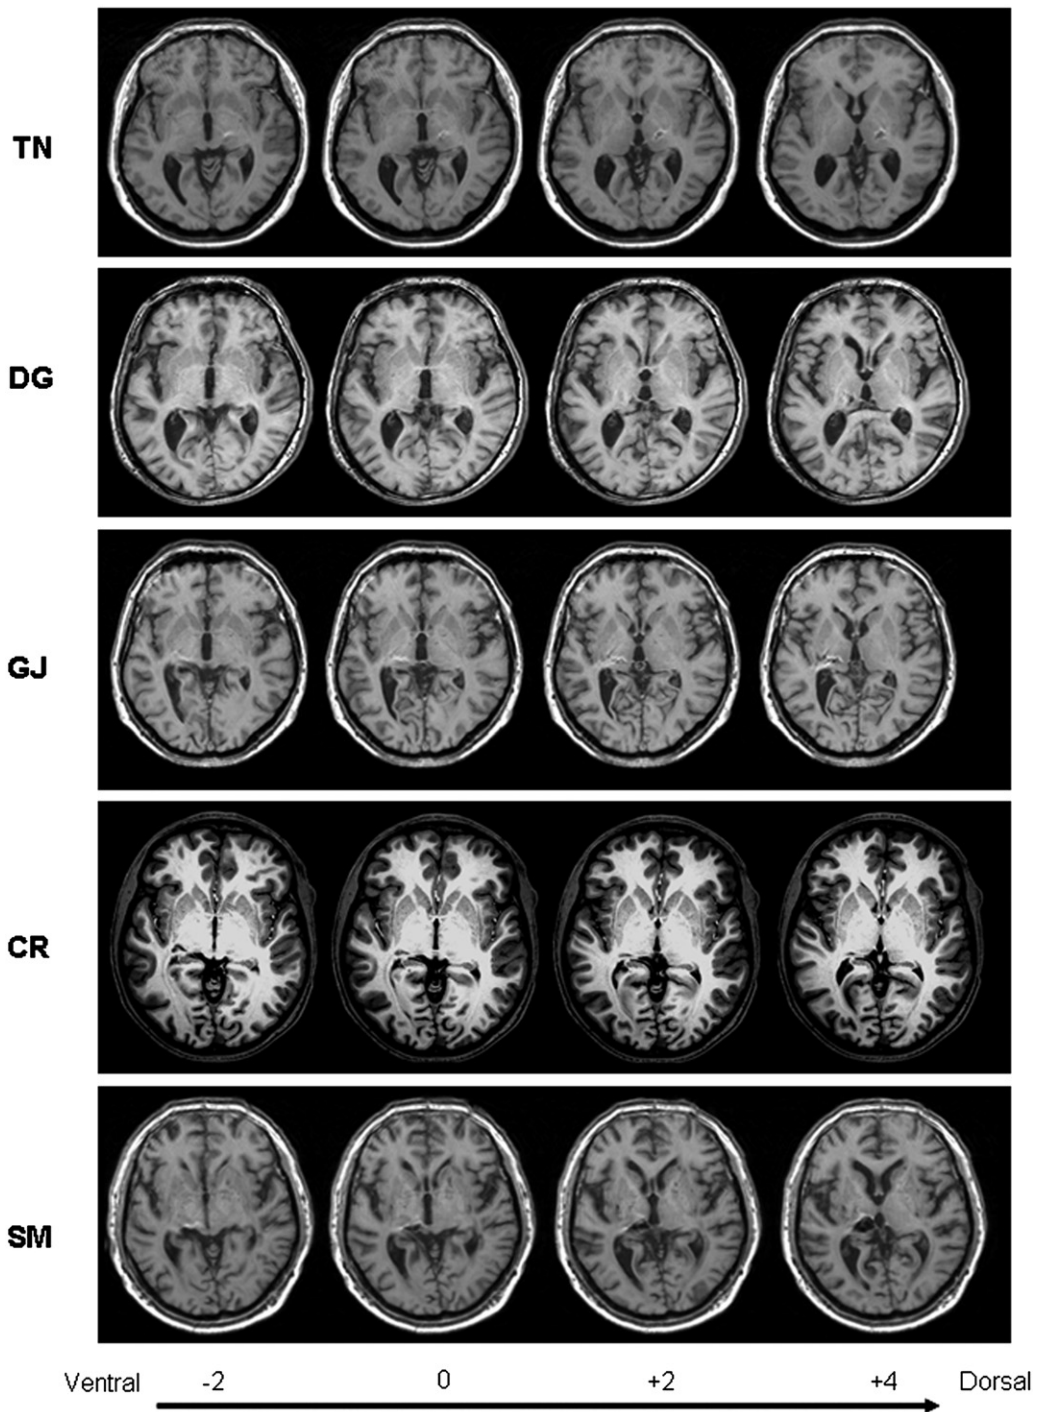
Reconstructed T1-weighted axial MRI images for each patient. Anatomical convention: slices running from ventral to dorsal and showing millimetres above or below the anterior-posterior commissural (AC-PC) plane.
